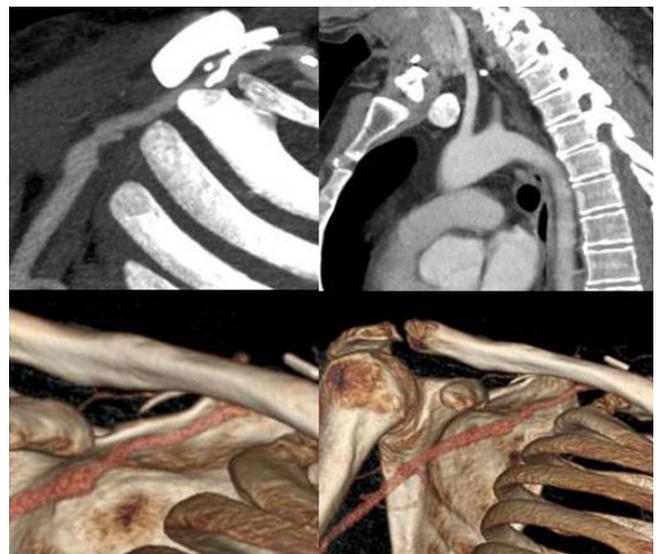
Computed tomography image of right subclavian angiogram 6 weeks post procedure. Revised right subclavian interposition vein graft after graft thromboses appears fully patent with no significant stenoses.
